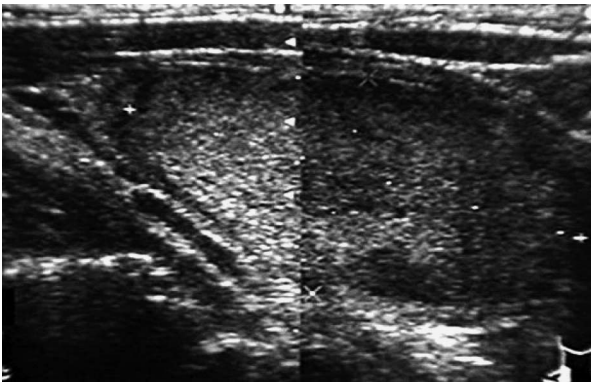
A tumor diameter of approximately 60 mm, solid and accounts for most of the left lobe were suggested by ultrasound. Although capsular invasion was unclear, Doppler examination were revealed abundant blood flow and high blood flow resistance value inside the tumor. The result of ultrasound suspected the malignancy.
